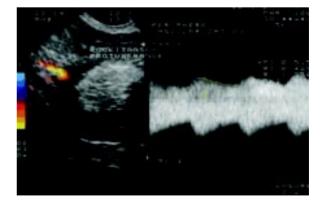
Color Doppler blood flow showing a low resistance index (RI = 0.27) in a malignant ovarian tumor.
